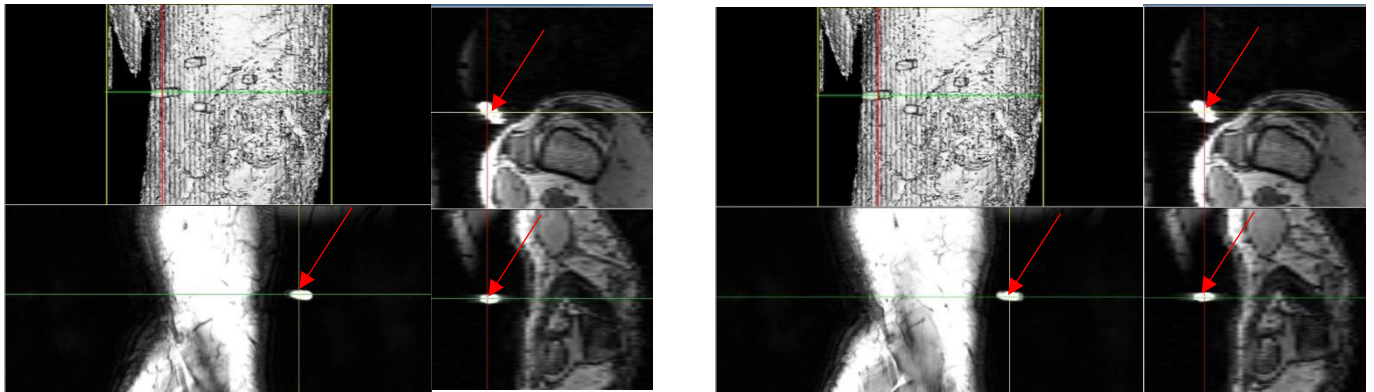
a) Left: MRI-marker centroid generated from segmentation (Analyze 12.0, Analyze Direct, Overland Park, KS, USA) – red arrows show the centroid positions in each of the planes – coordinates (36, 202, 114). b) Right: MRI-marker centroid that was visually-determined - red arrows show the centroid positions in each of the planes – coordinates (37, 204, 115)
